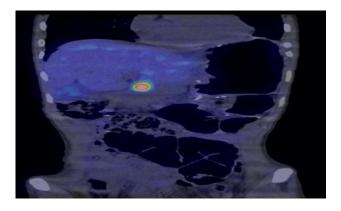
Somatostatin receptor scintigraphy, coronal reconstruction.
